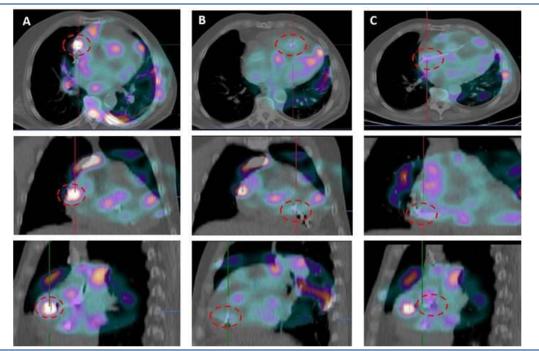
SPECT/CT images in axial, frontal and sagittal views (up down) 24 hours after labelled [^{99m}Tc]Tc-HMPAO WBC administration. High-intensity focal accumulation of labelled [^{99m}Tc]Tc-HMPAO WBC in the right atrial electrode site (A), medium-intensity foci of hyperfixation along the lead in the right ventricle (B) and in the ventricular electrode fixation site (C) (highlighted in red) are visualized in the images
